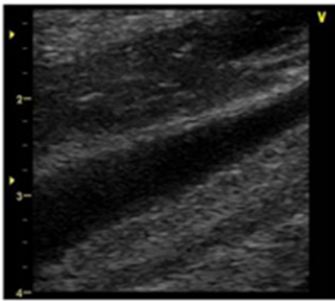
Case 2. Ultrasonogram showing no obvious thrombus in the right internal jugular vein on postoperative day 2.
